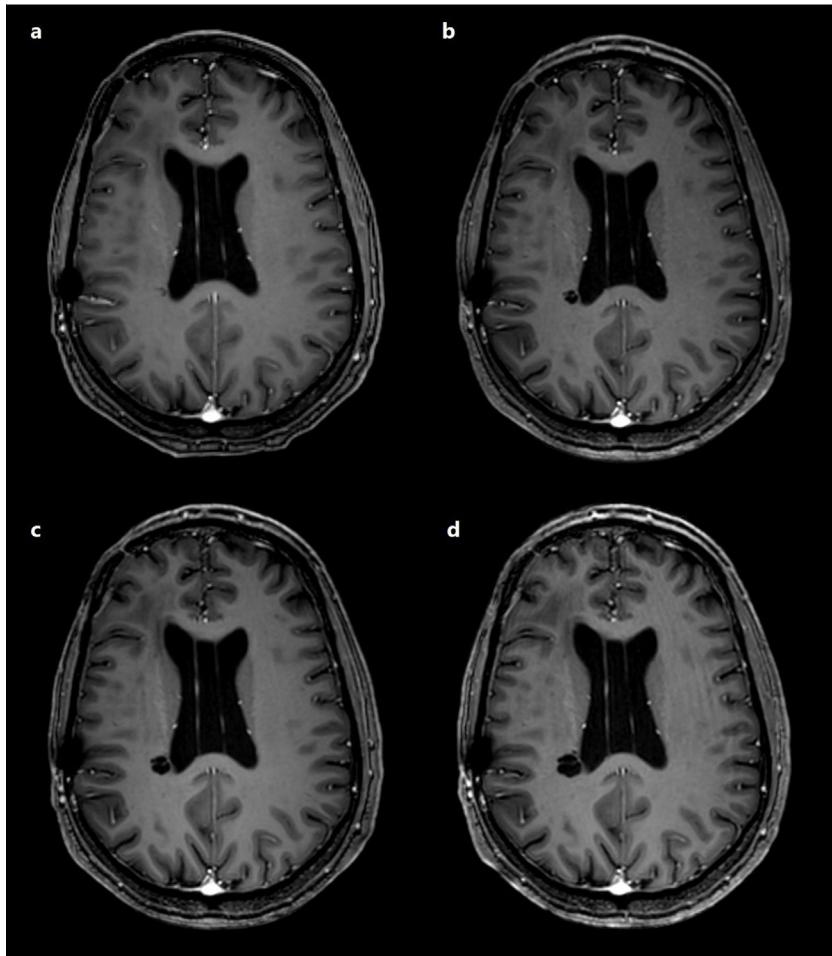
Contrast-enhanced T1-weighted 3D-SPGR MRI studies: follow-up studies performed in 2017, 2018, 2019, and 2020 (images a-d, respectively). The images show progressive growth of a round lesion in the right corona radiata, isointense to CSF and without enhancement.
